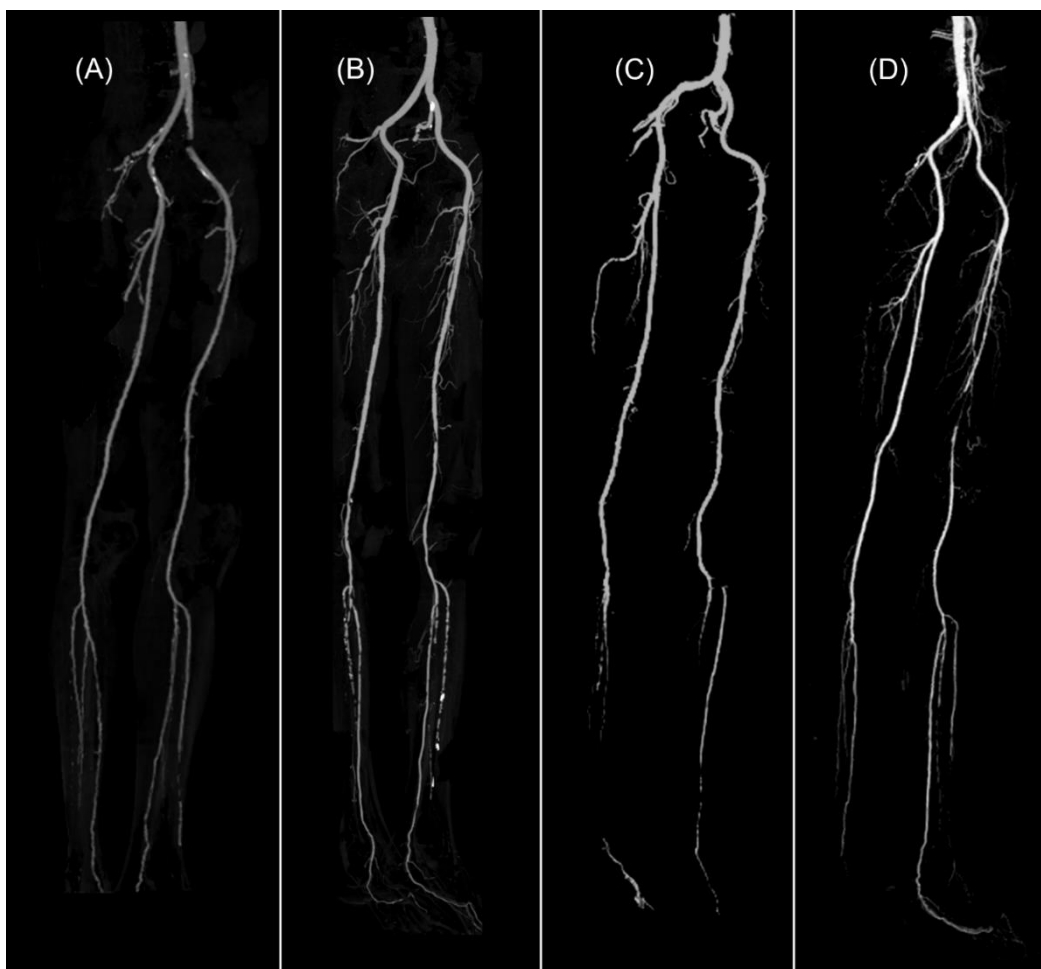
A MIP of a lower limb vessels. CT images of a (A) 55 years old male patients scanned with protocol A, (B) 72 years old male patients scanned with protocol B, (C) 70 years old female patient scanned with protocol C, and (D) 63 years old male patient scanned with protocol D.
